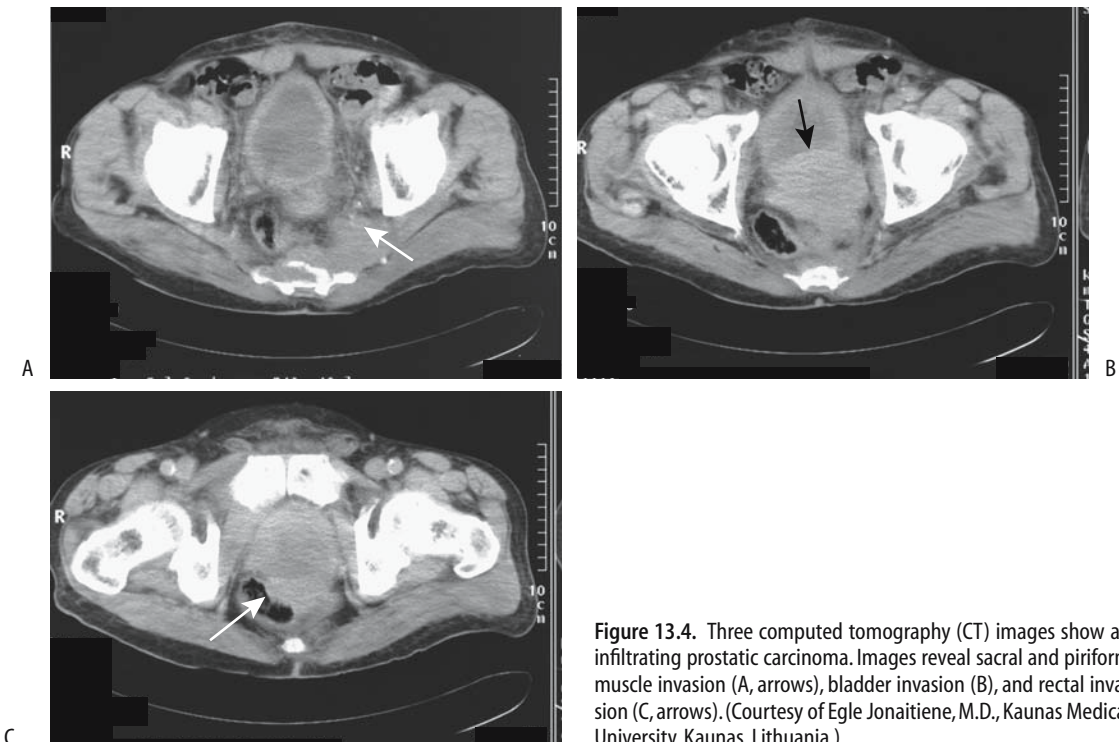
Three computed tomography (CT) images show an infiltrating prostatic carcinoma. Images reveal sacral and piriform muscle invasion (A, arrows), bladder invasion (B), and rectal invasion (C, arrows). (Courtesy of Egle Jonaitiene, M.D., Kaunas Medical University, Kaunas, Lithuania.)
